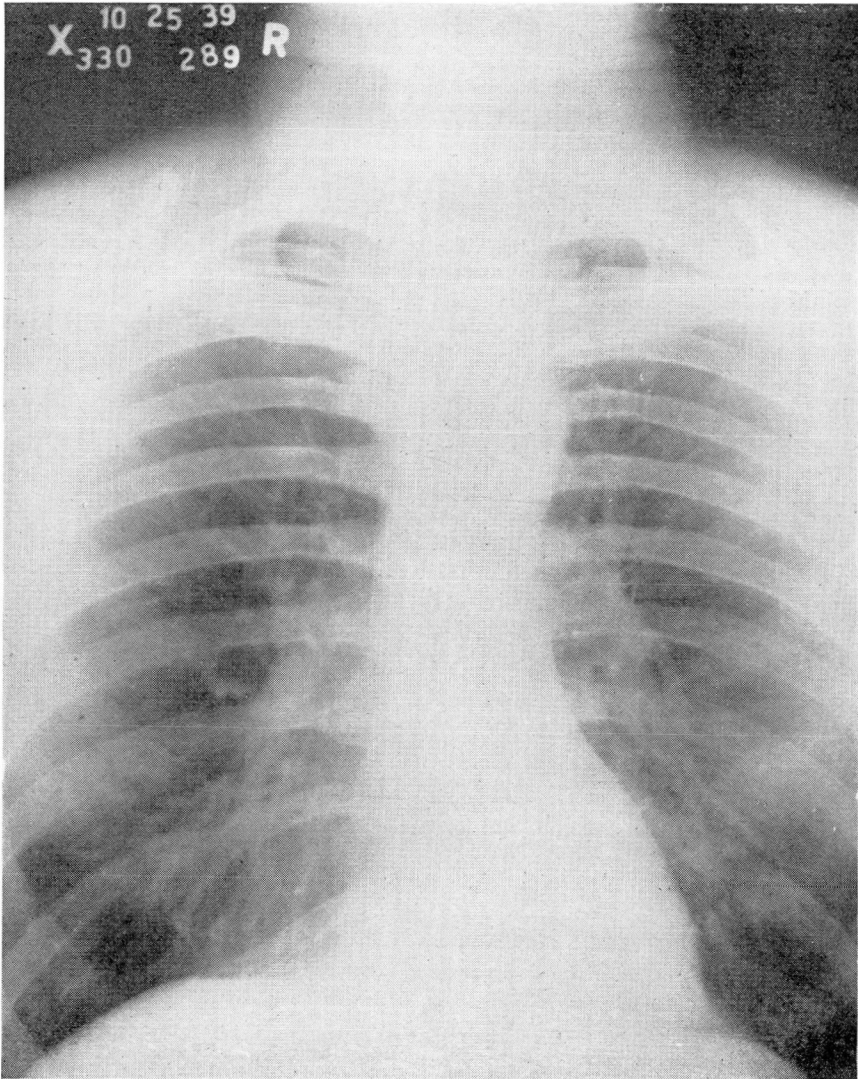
Roentgenogram taken at time of initial examination, showing the parenchymal infiltration extending from each hilum.
